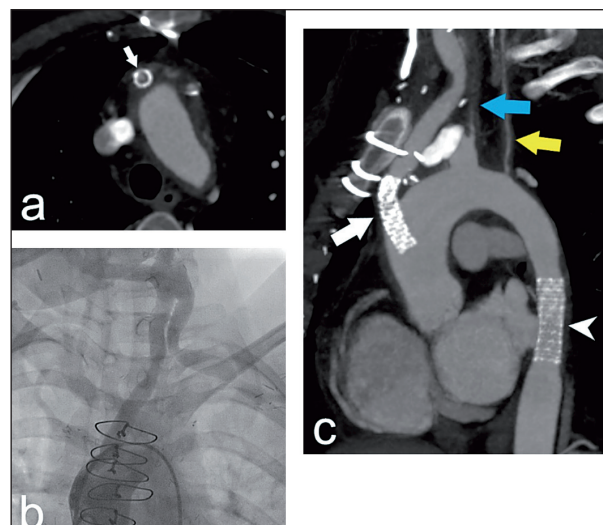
a) CT angiography- restenosis in the stent placed at the stenotic part of the bypass between ascending aorta and left ACC (white arrow). b) Catheter angiography - stenosis of the bypass between ascending aorta and left ACC. Bypass between left ACC and left axillary artery due to stenosis of the left subclavian artery. Bypass between left and right ACC due to severe stenosis of the right proximal part of ACC. c) CT angiography – stent placed into aortocarotid (left) bypass (white arrow), stent placed in stenotic part of descending aorta (arrowhead). Subocclusive stenoses of the left ACC (blue arrow) and left subclavian artery (yellow arrow).
